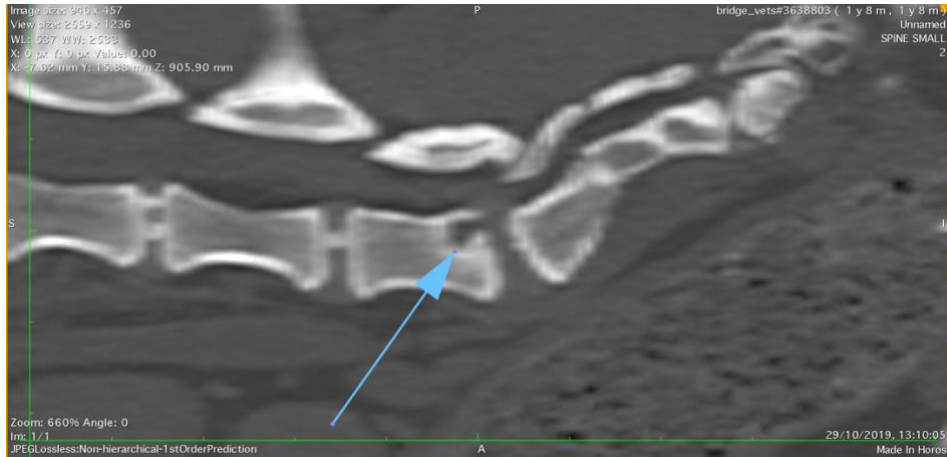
CT 3D MPR Sag lumbo-sacral
